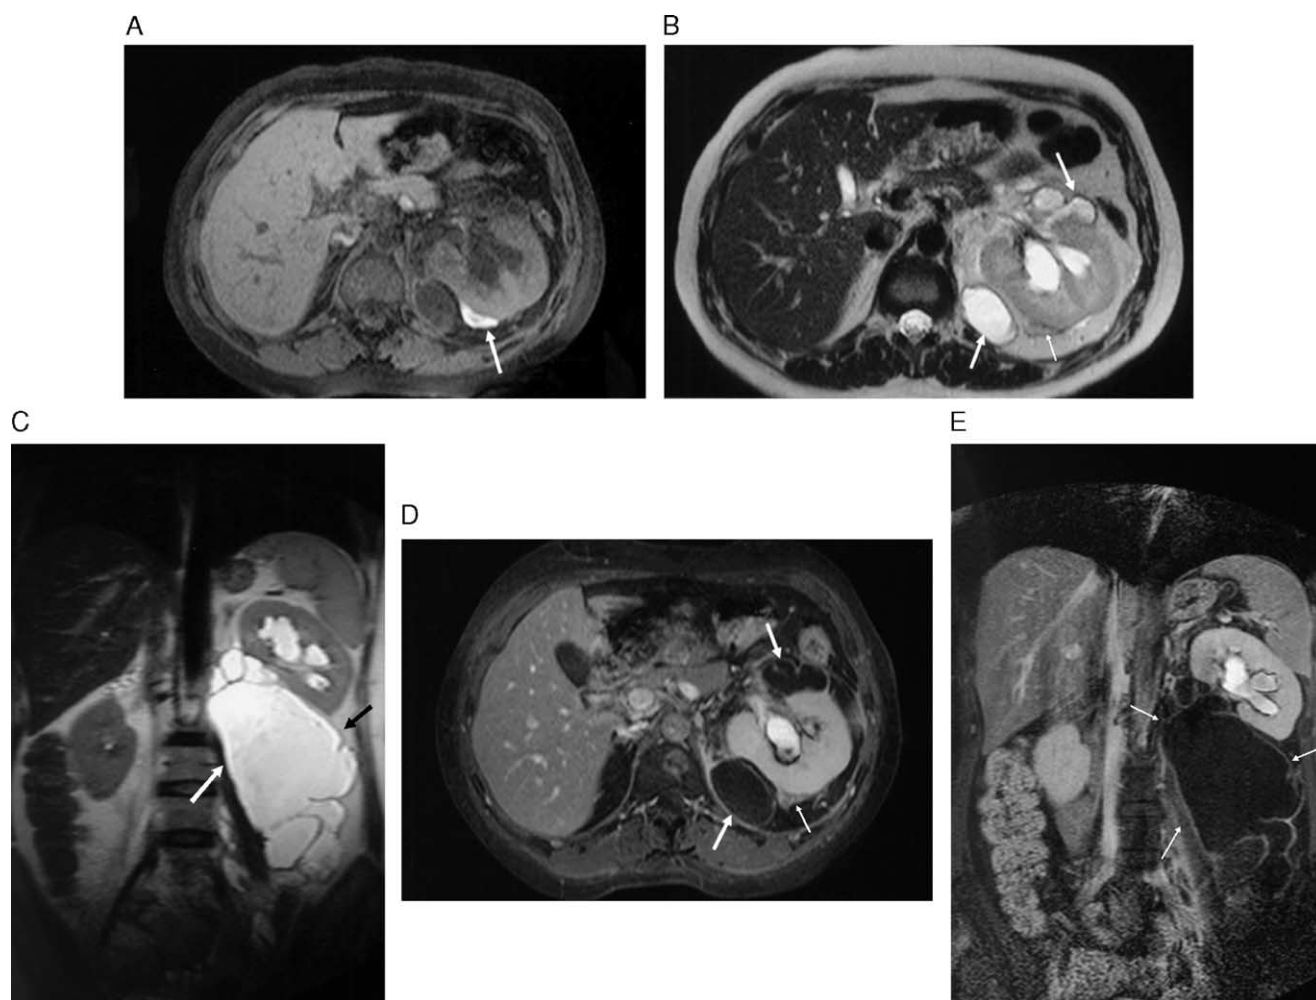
Urinoma formation secondary to traumatic perirenal rupture of a long-standing hydronephrosis. (A) Axial T1-weighted fat-saturated SGE image (TR/TE/FA, 158/4.2/80) revealing a thin subcapsular subacute hematoma secondary to trauma (arrow). T2-weighted half-Fourier single-shot fast spin echo images in axial (B) and coronal (C) planes (TR/TE,  $\infty$ /90) revealing hyperintense fluid collections in the perirenal space (thick arrows) with a thin rim. On axial T2-weighted half-Fourier single-shot fast spin echo image, the subcapsular hematoma is hypointense (thin arrow, B). On late postcontrast T1-weighted fat-saturated SGE images (TR/TE/FA, 178/4.2/80) in axial (D) and coronal (E) planes, the urinoma has a hypointense content with rim enhancement (arrows, D and E); the subcapsular hematoma is marked with a thin arrow on the axial late contrast-enhanced images (D and E).
